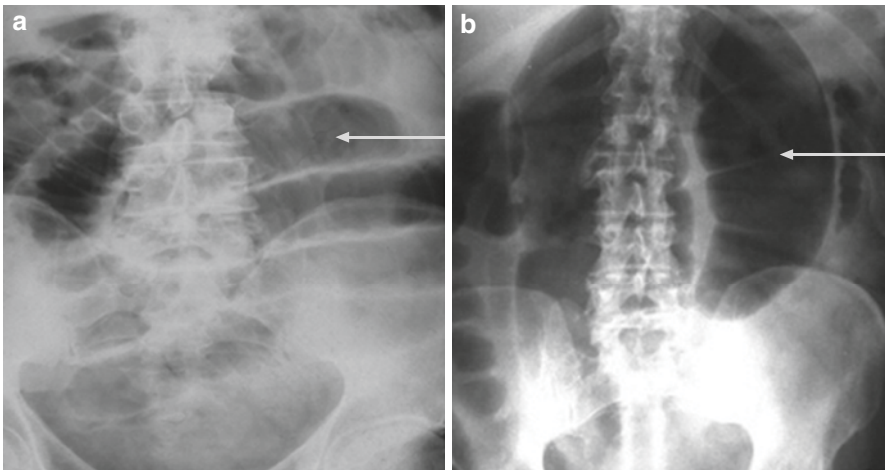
Abdominal X-ray: small bowel versus large bowel. (a) Small bowel obstruction. Note the valvulae conniventes (*arrow*) crossing the whole width of bowel. (b) Volvulus of the sigmoid colon. Note the haustra crossing a portion of bowel width (*arrow*)
